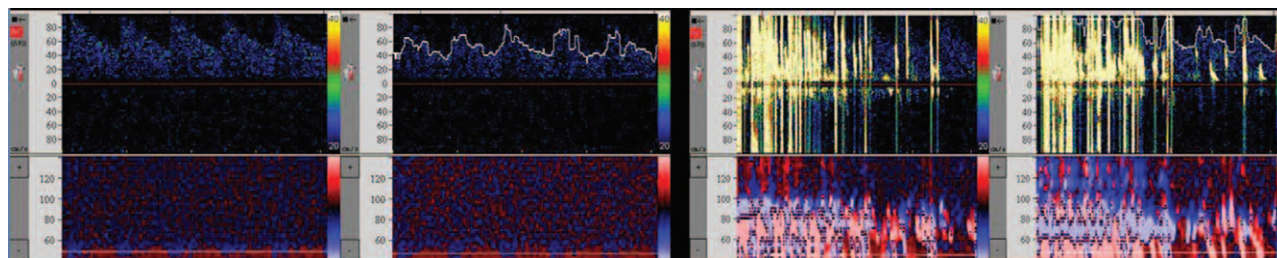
Bilateral multifrequency transcranial Doppler monitoring of middle cerebral arteries. Representative transcranial Doppler picture showing a baseline curve (left) and a burst of microembolic signals (right; high-intensity transient signals) during pulmonary vein angiography.
